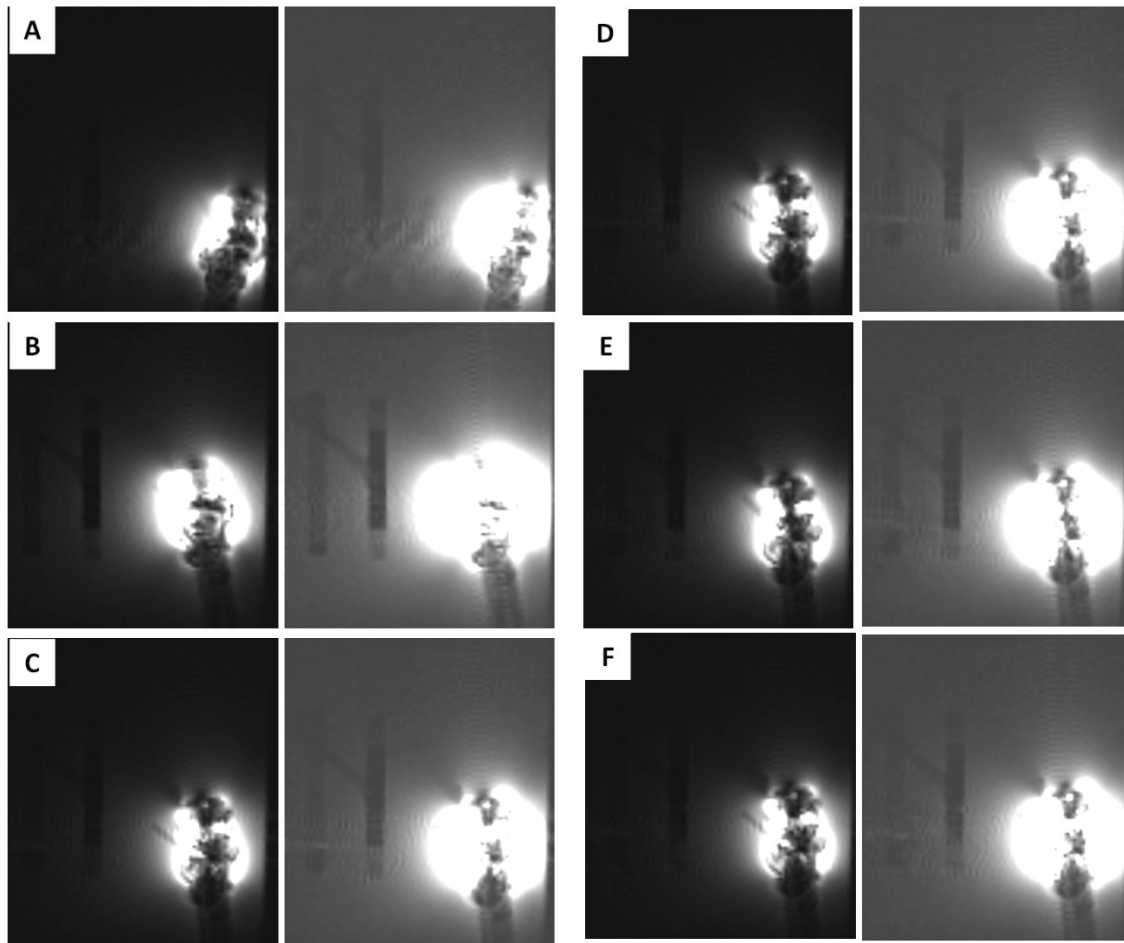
MRI guidance series, with the six images (A-F) displayed in the order that they were acquired during the alignment test. On the left the image is displayed with increased contrast (WC = 240, WW = 560) to visualise the catheter, while the right image display is brighter (WC = 80, WW = 220) to visualise the bile duct.
